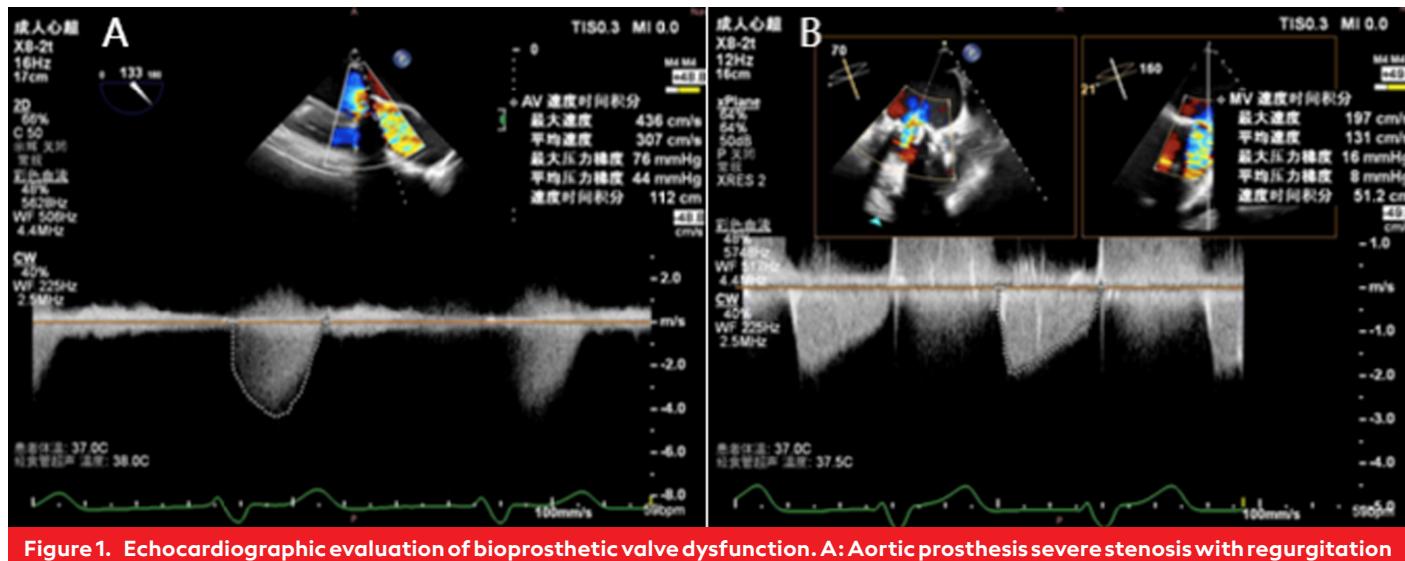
Echocardiographic evaluation of bioprosthetic valve dysfunction. A: Aortic prosthesis severe stenosis with regurgitation (mean gradient 44 mm Hg; peak velocity 5.7 m/s, VCW 8 mm). B: Severe mitral bioprosthetic regurgitation (VCW 8 mm, mean gradient 8 mm Hg).
